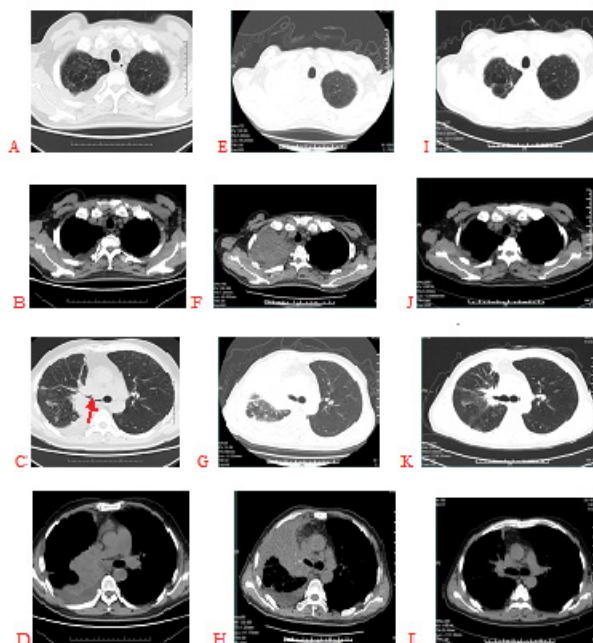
(A-D) Lung and mediastinal windows of computed tomography (CT) before nivolumab administration shows right pulmonary portal mass and right pulmonary dissection; (E-H) computed tomography (CT) after 2 cycles of nivolumab administration shows tumor reduction; (I-L) Computed tomography (CT) after 4 cycles of nivolumab administration shows significant reduction of tumor and mediastinal lymph nodes.
